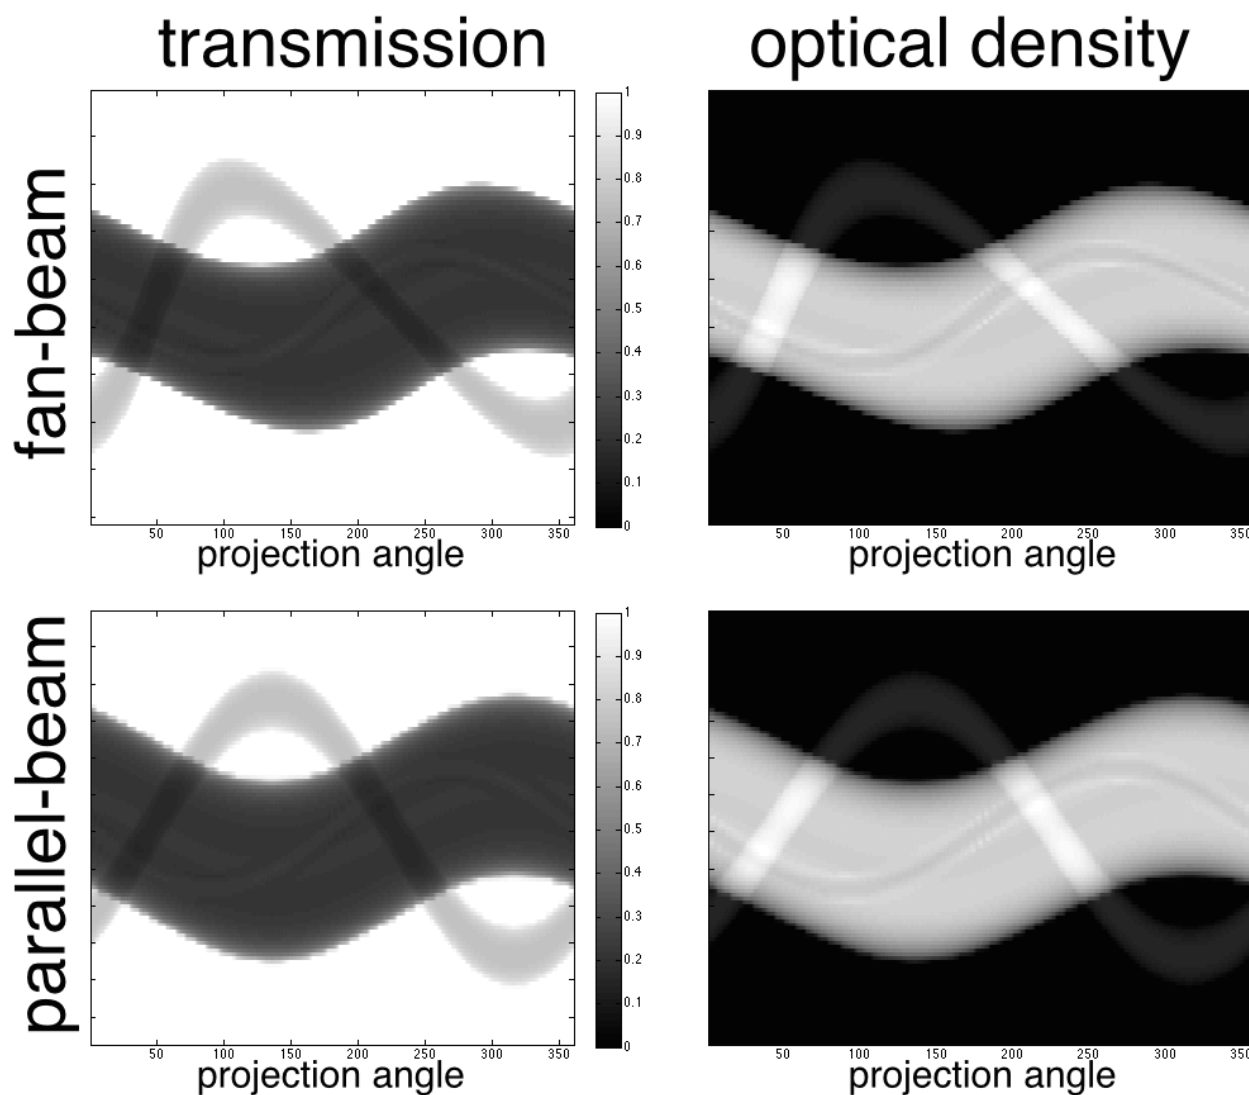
In order to reconstruct an image of the test object with reasonable accuracy, many projections are obtained through the object at many different projection angles. A collection of these projections organized by projection angle is referred to as a sinogram. Here, fan-beam and parallel-beam CT geometries were used to collect transmission sinograms of the test object, which can then be used to calculate optical density sinograms. Here, the mirrored redundancy of the front 180° and back 180° of parallel-geometry data is easily recognizable.
